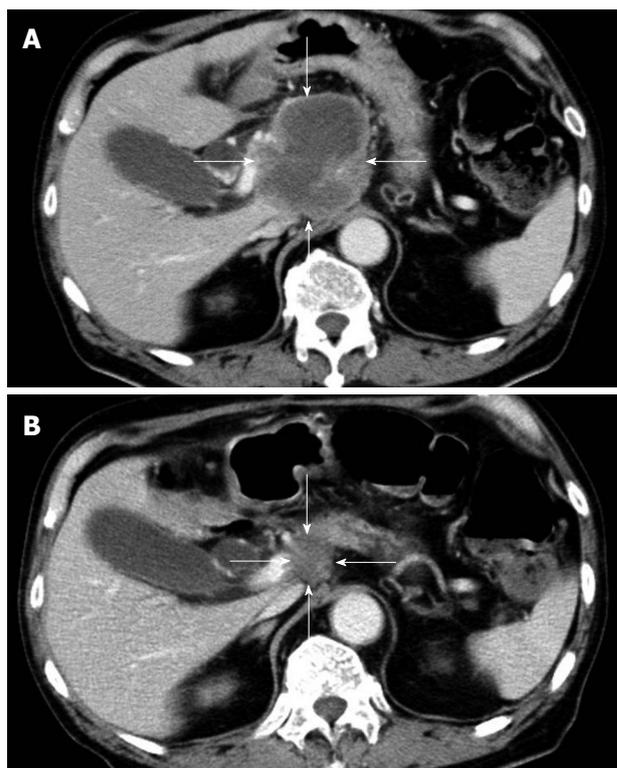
Contrast-enhanced computed tomography scan of the abdomen. A: There was a low-density mass, 7.5 cm in diameter, in the head of the pancreas at the time of admission. The pancreatic tumor (arrows) did not show contrast enhancement; B: A follow-up computed tomography scan showed that the pancreatic mass had reduced to 2.0 cm in diameter. The tumor (arrows) had markedly regressed 4 mo after starting chemotherapy with gemcitabine.
